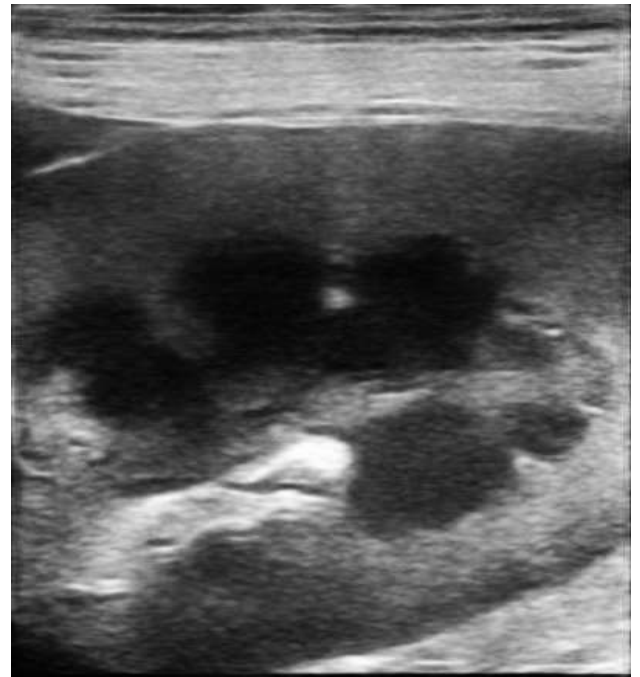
Sonogram showing an ill-defined cortico-medullary junction of the kidney.
